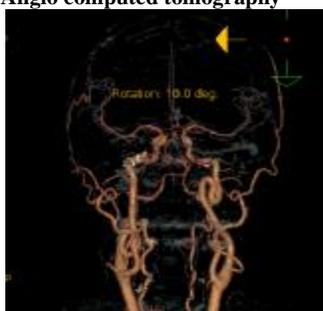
Angio computed tomography
